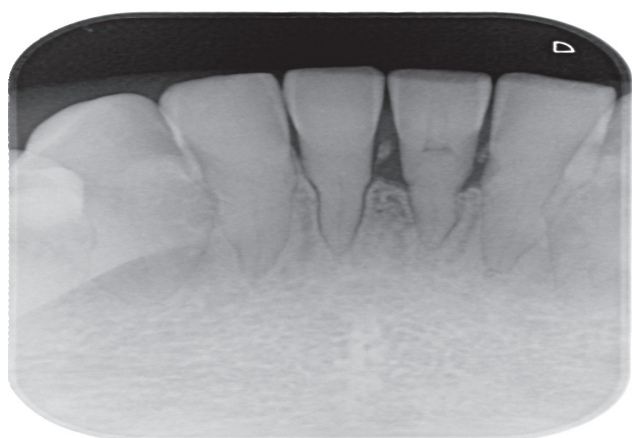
Periapical radiographs of the patient exhibiting bone loss
